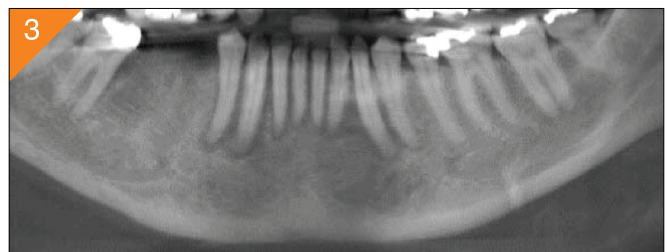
Cropped panoramic reconstruction from CBCT data.
